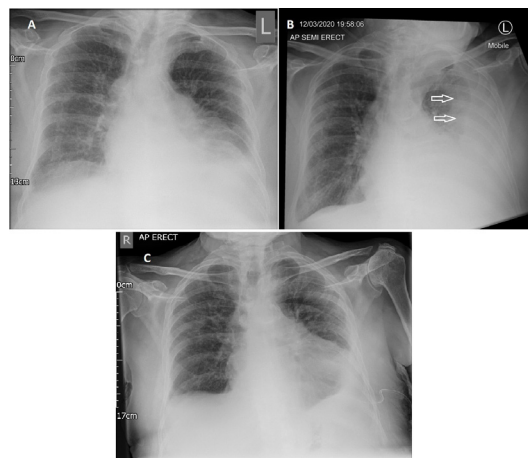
(A, B) Two chest X-rays 30 hours apart showing significant increase in the left pleural effusion but no obvious rib fractures. (C) Follow-up chest X-ray showing chest drain in situ and drainage of most of the left pleural effusion.
